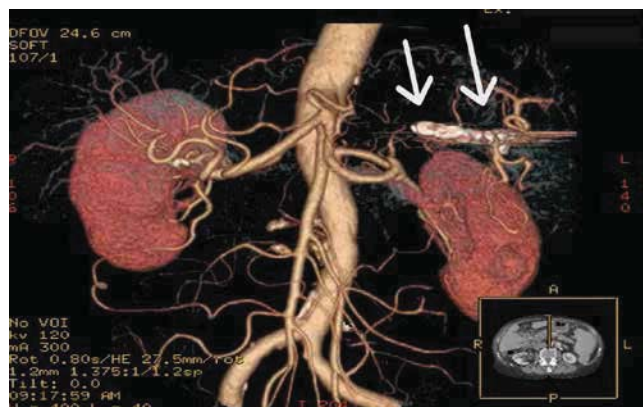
Representative 12-month post-embolization 3D CT angiography. The image demonstrates a compact, stable cluster of metallic coils (white arrows) with markedly attenuated splenic arterial flow and no evidence of recanalization, consistent with a durable and well-maintained hemodynamic response
